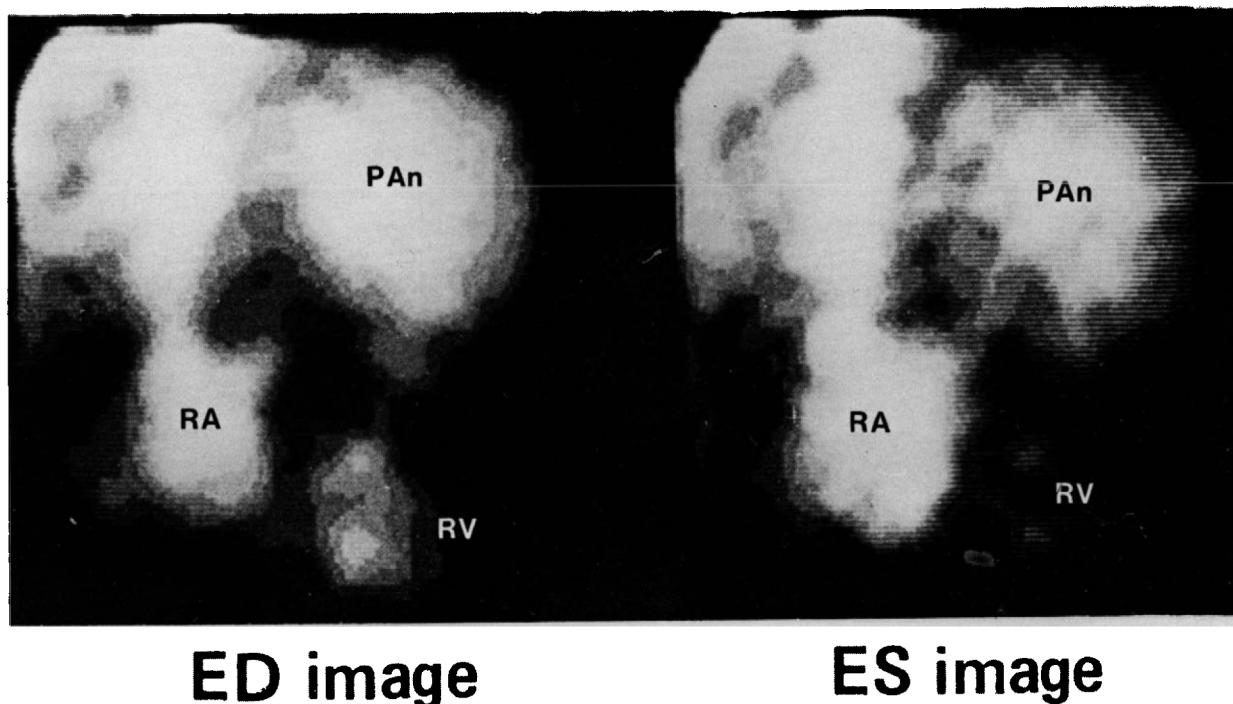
Gated equilibrium krypton-81m scintigram in right anterior oblique view showing the right atrium (RA), the right ventricle (RV) and a massive pulmonary aneurysm (PAn). ED=end diastole, ES=end systole.
